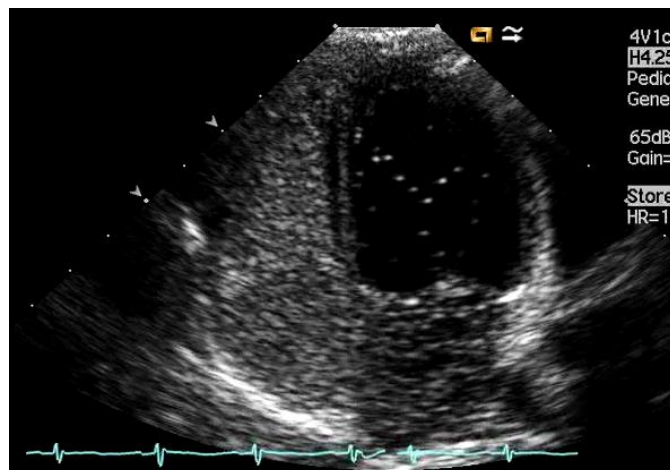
Positive transthoracic contrast echocardiography in PAVM.
